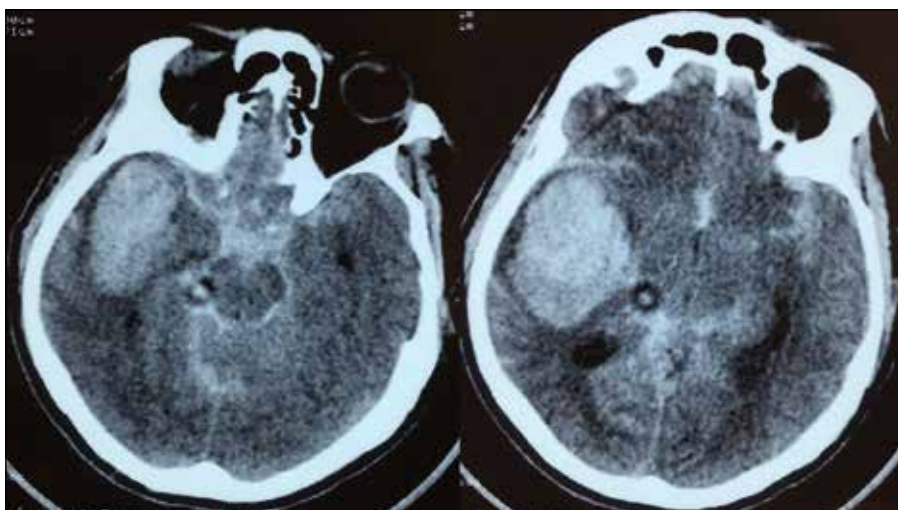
The patient's pre-operative, unenhanced axial cranial CT images at admission to the hospital.
